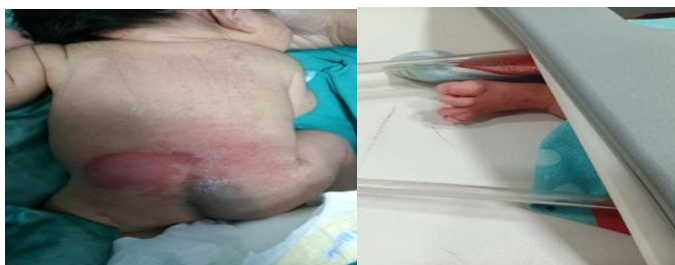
case 1: preterm 7days neonate with ambiguous genitalia, imperforate anus, para midline left lower back pigmented swelling, single kidney and fused toes. A) Transverse USG at site of swelling showed lower lumbar posterior arch defect through which a skin-covered left para midline cystic lesion contains spinal cord, nerve roots and CSF as well are seen protruded. b) Longitudinal USG showed the defect with the cord, nerve roots, neural placode and CSF are seen within skin covered cyst(myelomeningocele). C) Longitudinal USG showed dilated central spinal canal with fluid at dorsal and lumbar regions (hydromyelia). D) Axial T2W MRI show right single kidney. E) Axial T2W MRI show posterior arch defect at level of L2 down to L5 with para vertebral cystic lesion protruded through contain spinal cord, nerve roots, neural placode and CSF. (myelomeningocele). F) Sagittal T2W MRI show the para midline lesion. G) Sagittal T2W MRI show dilatation of central spinal canal at dorsal and lumbar region(hydromyelia). H) Coronal T2 HASTE MRI show the para midline previously described lesion. Final diagnosis is (myelomeningocele with syringohydromyelia). Agreement frequency between USG and MRI finding =100%.
